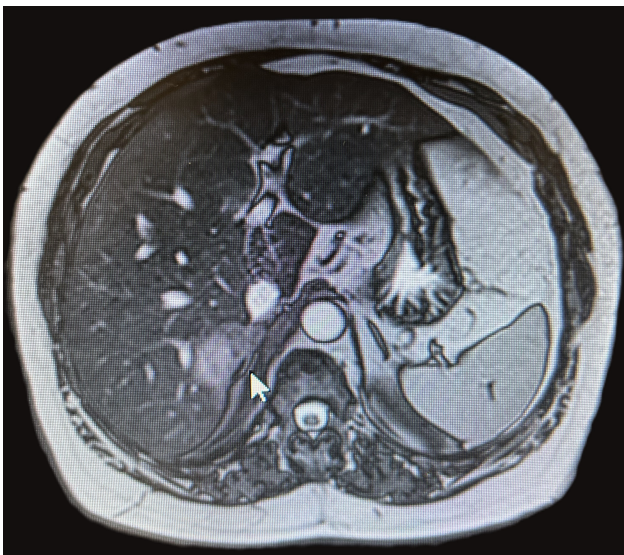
Magnetic resonance imaging (MRI) images, the lesion is located under the liver capsule and is about the right adrenal in the lower sections (arrow head).
